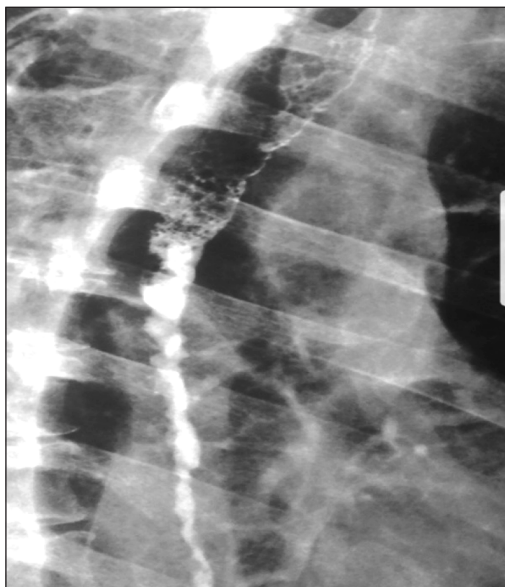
Radiography – esophageal post caustic stenosis.
